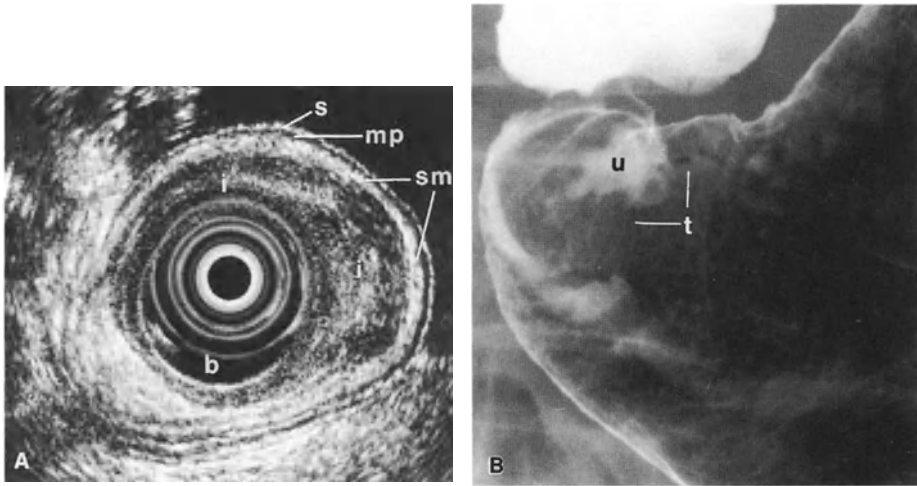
A Endoscopic sonogram showing hypoechoic infiltration (*i*) into the submucosal layer (*sm*) without penetration into the muscularis propria (*mp*) and serosal layer (*s*). *b*, water-filled balloon. B Corresponding radiogram, showing a smooth round double contour (*t*) with a central ulcerative lesion (*u*)
